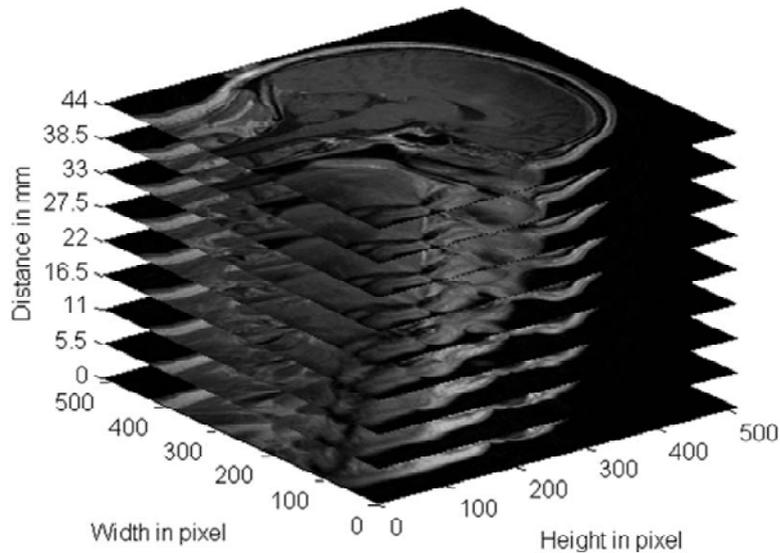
An MR image sequence with 5.5 mm spacing between slices [4]
